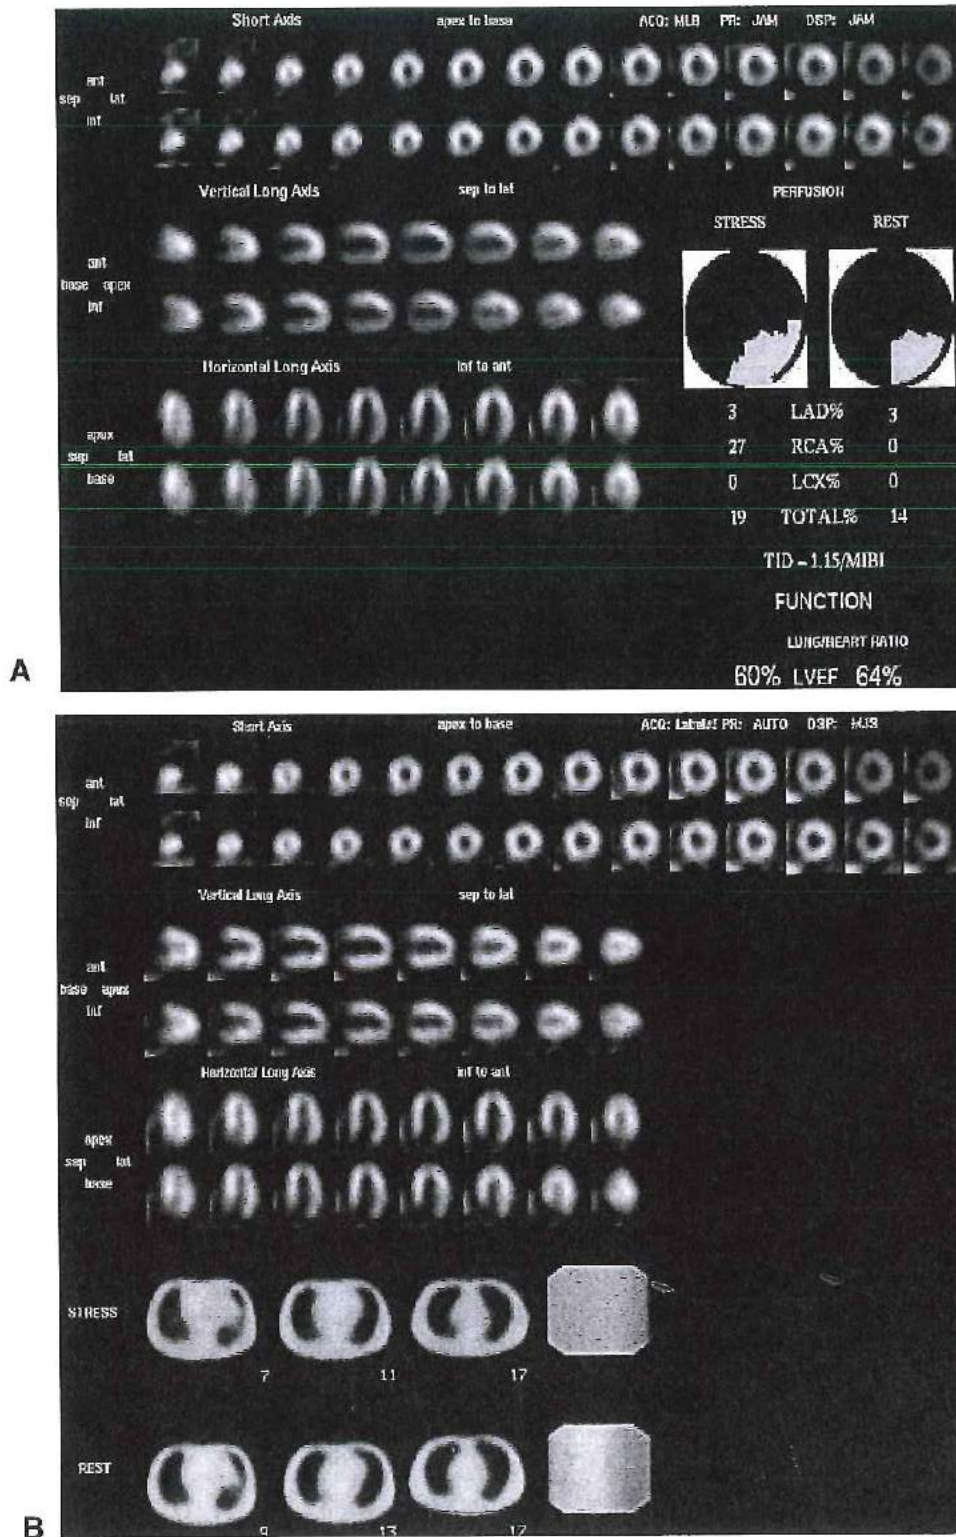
A, Exercise-rest Tc-99m sestamibi SPECT study in a large man depicting a persistent reduction of activity in the inferior and inferolateral regions of the left ventricle, suggestive of a prior infarction. B, Attenuation-corrected images reveal normal perfusion in all regions. Attenuation map samples and daily reference scans are shown for quality control.
